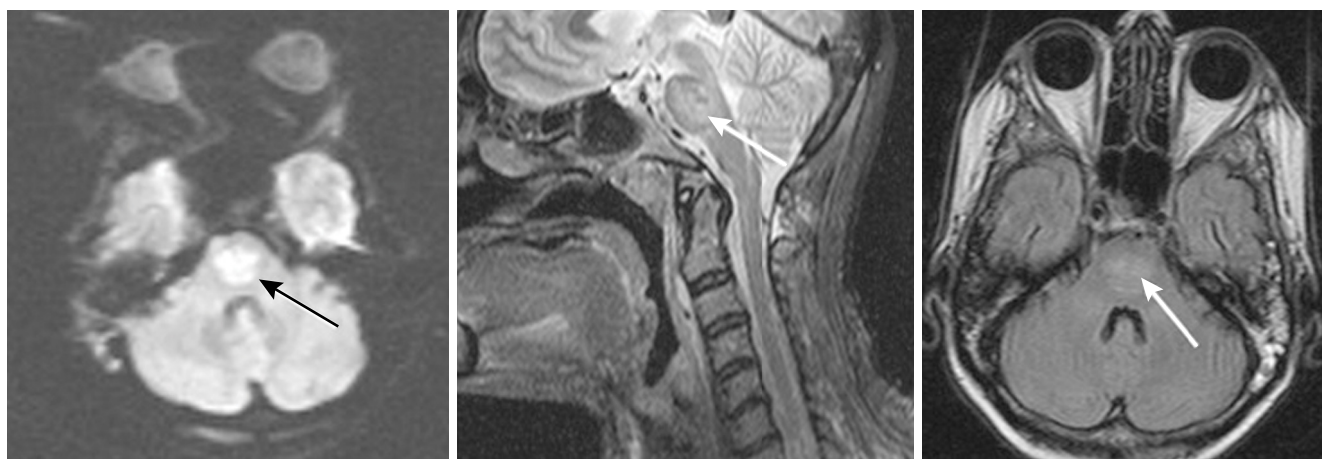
Brain MRI discloses a hyperintense signal in the pons, in a transplant recipient (liver transplantation) with pontine myelinolysis.
